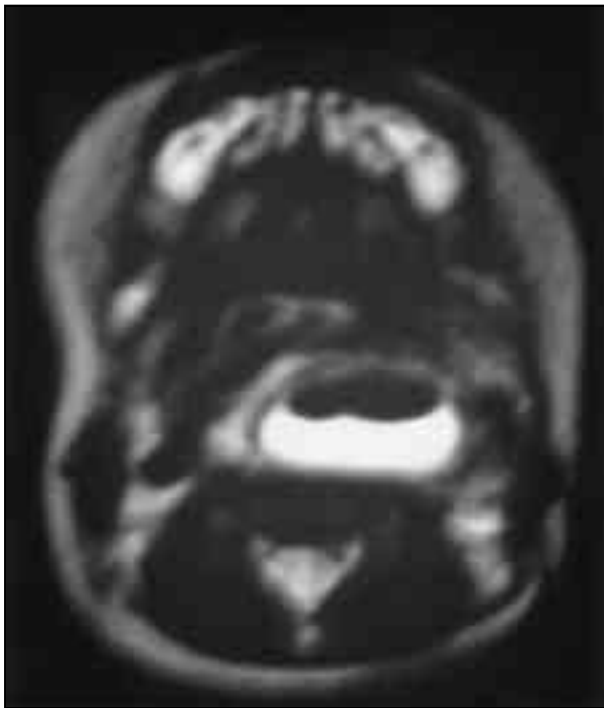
MRI neck T2W axial image showing globular lesion with air-fluid levels and isointense rim in retro and left parapharyngeal spaces
